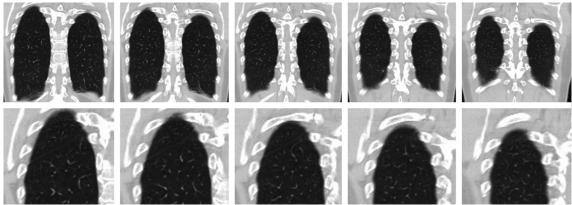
Coronal CT section images 75 to 79, with enlargements of the top of the right lung shown below. The shift to each image is indicated in Excerpt 3 by #75, #76 and so on.
